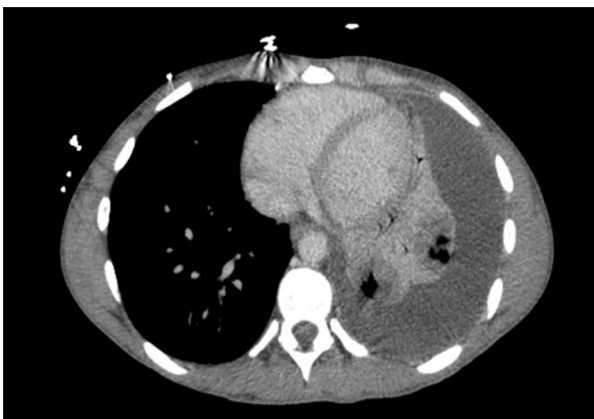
CT chest showing large pleural effusion on left representing empyema. Multiple pulmonary nodules showing cavitation are probably septic emboli.
